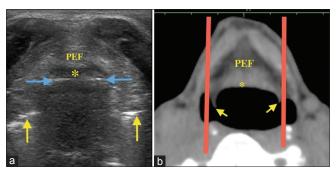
(a) Oblique axial section just below the level of hyoid bone demonstrating the sonoanatomy of step 5 structures, using linear transducer. (b) corresponding computed tomographic section (red lines – representing the limit of ultrasound scan extent) PEF: preepiglottic fat; asterisk, hypoechoic epiglottis; Blue Arrows, Hyperechoic Air-mucosal interface of posterior surface of epiglottis; Yellow arrows, Hyperechoic Air-mucosal interface of vestibular ligaments
